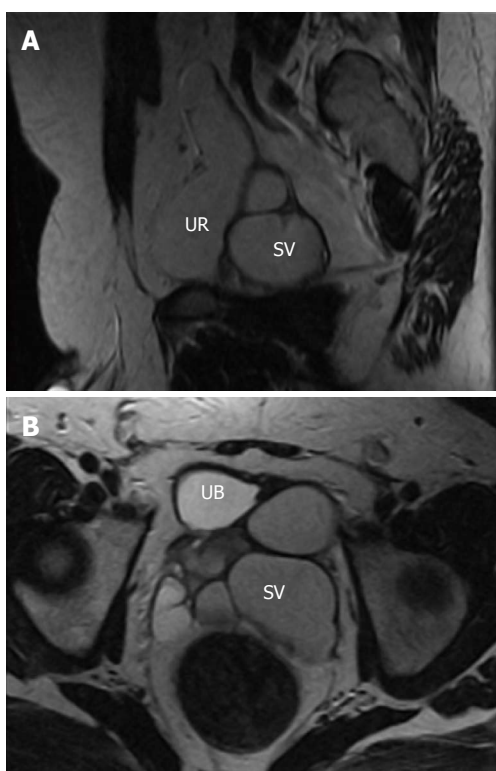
Sagittal T2-weighted magnetic resonance imaging. A: The left ureter stump with ectopic insertion into the dilated left seminal vesicle (SV); B: Altered fluid content at the dilated left seminal vesicle with relative low small intestine. UB: Urinary bladder; UR: Ureter.
